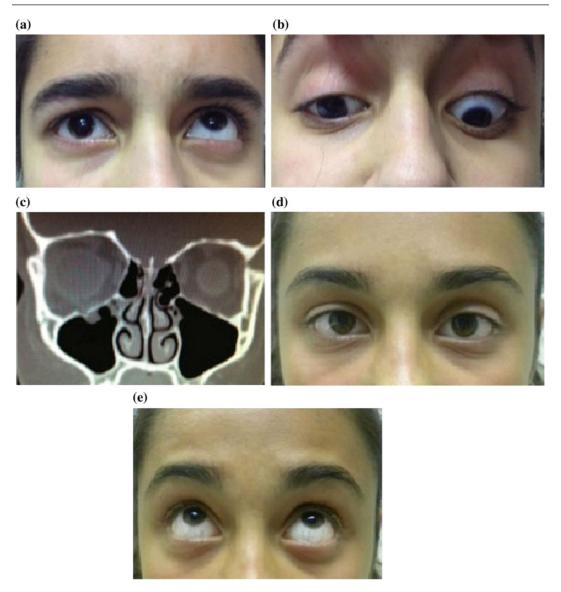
Clinical photographs at presentation of a young girl who suffered blunt periocular trauma showing restricted right supraduction (a) and infraduction (b). c Coronal orbital CT scan confirming an entrapped right
